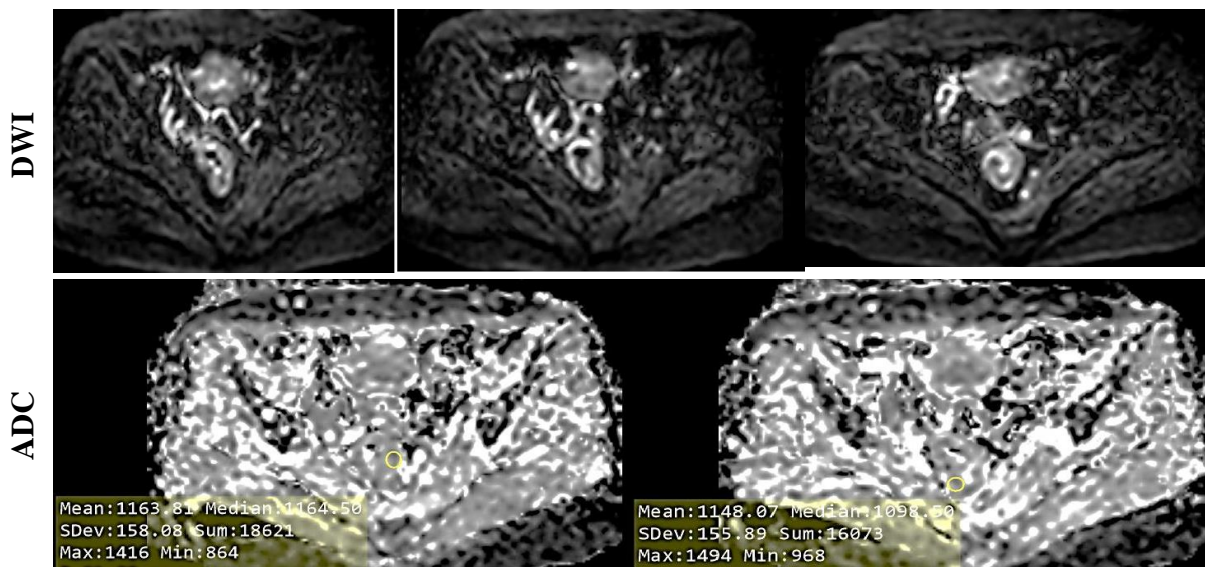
A 50-year old female patient presented with abdominal pain & bleeding per rectum since 6 months. Colonoscopy and biopsy showed moderately-differentiated adenocarcinoma. Pretreatment MRI pelvis revealed irregularly marginated moderately circumferential mucinous mass in mid and lower rectum with narrowing of the lumen; 2.2 cm from anal verge, with invasion of external anal sphincter; MRF invasion (T3); 12 mm beyond Musculosa Propria (T3c); CRM positive (< 1 mm); preserved fat plane between the mass & posterior uterine margin; 3 mesorectal LNs (suspicious for metastasis) (N1); ADC = $1.197 \times 10^{-3} \text{ mm}^2/\text{s}$ (consistent with moderately-differentiated tumor) → [T3c N1]. Post-treatment MRI pelvis (4 months later) revealed irregularly marginated moderately circumferential mucinous mass in mid and lower rectum with narrowing of the lumen; 3 cm from anal verge, with invasion of external and internal anal sphincters with left intersphincteric marginally cavity; MRF invasion; 23 mm beyond Musculosa Propria (T3d); CRM positive (< 1 mm); absent fat plane between the mass & posterior vaginal wall (recto-vaginal fistula) (T4d); 2 mesorectal LNs (suspicious for metastasis) (N1); ADC = $1.148 \times 10^{-3} \text{ mm}^2/\text{s}$ [the mean ADC equation: $1.148 - 1.197 = -0.49 \times 10^{-3} \text{ mm}^2/\text{s}$] → [T4d N1]. (Progressive course)
